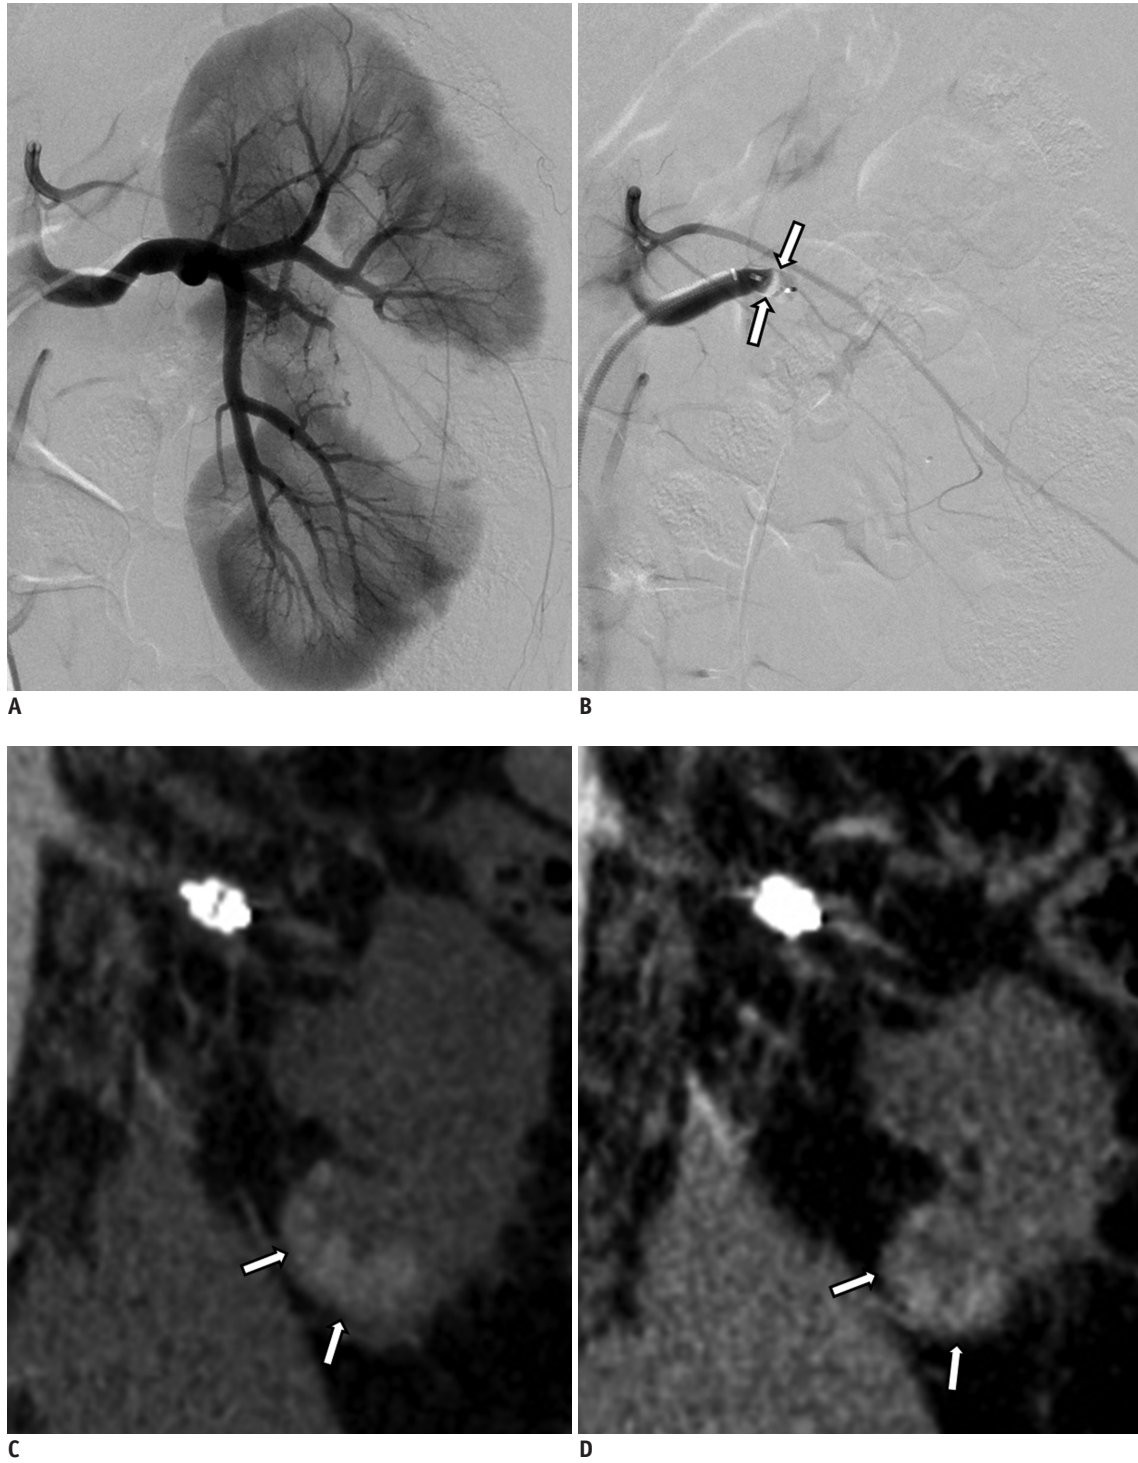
23-year-old male patient (No. 11) with hematuria caused by traumatic left kidney rupture. A. Renal arteriography shows parenchymal defect due to his shattered kidney (AAST grade IV). B. Arteriogram obtained after embolization reveals successful occlusion of left renal artery (arrows) using two vascular plugs. C, D. Follow-up CT scans obtained four (C) and ten (D) months following embolization show progressive renal atrophy with residual partial enhancement at lower pole (arrows).
